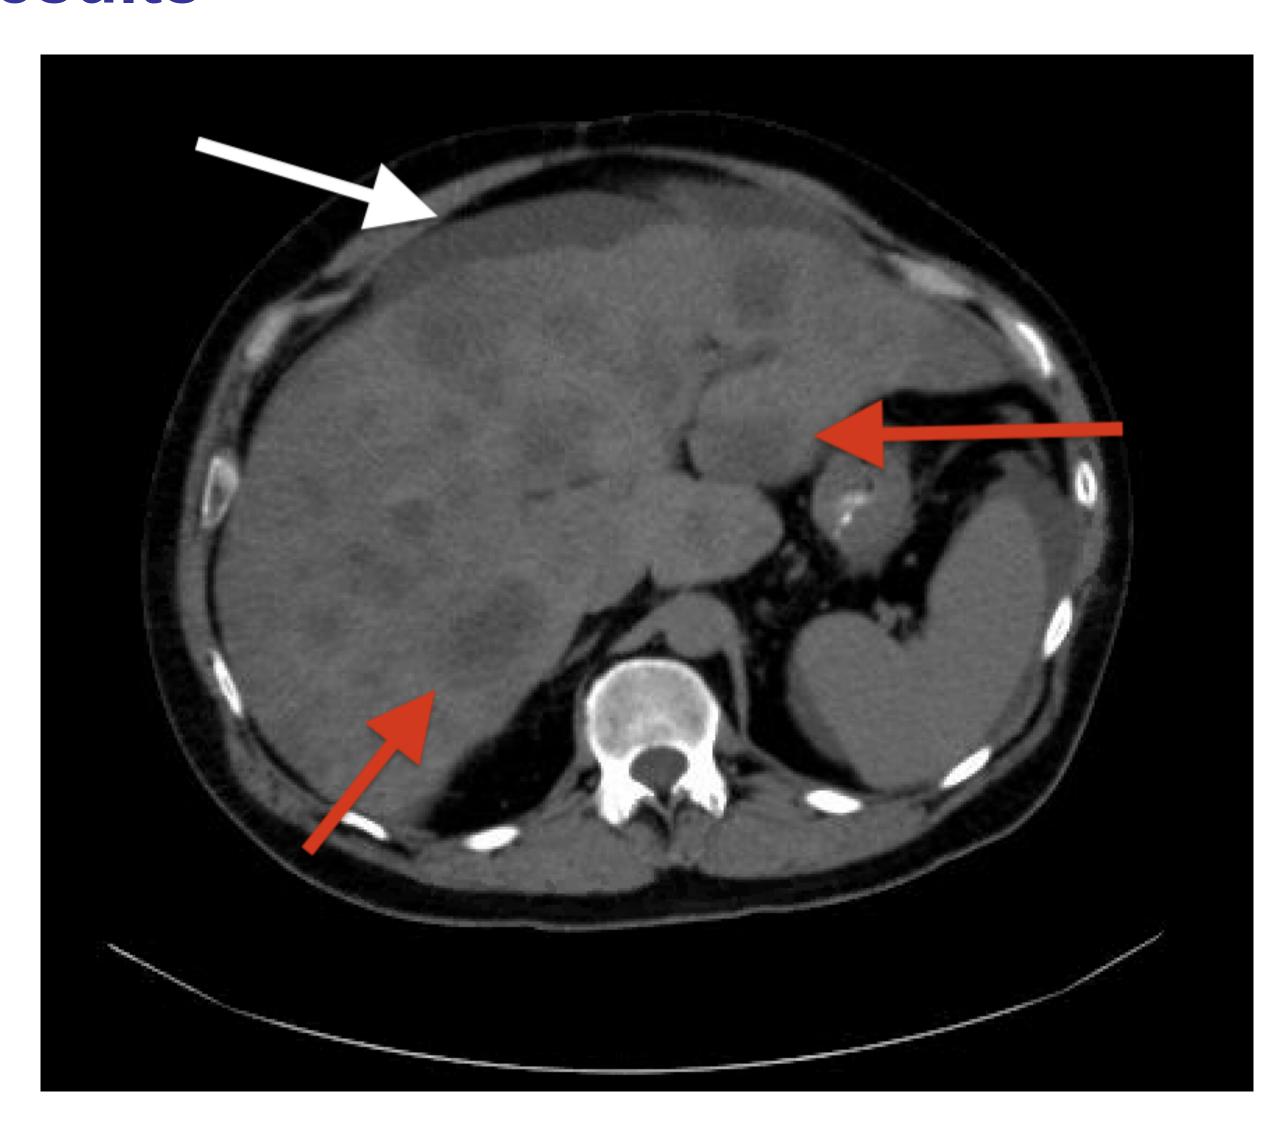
CT of the abdomen, showing numerous lesions throughout the grossly enlarged liver by red arrows. There is a nodular contour the liver surface. Mild perihepatic ascites seen as (white arrow)
